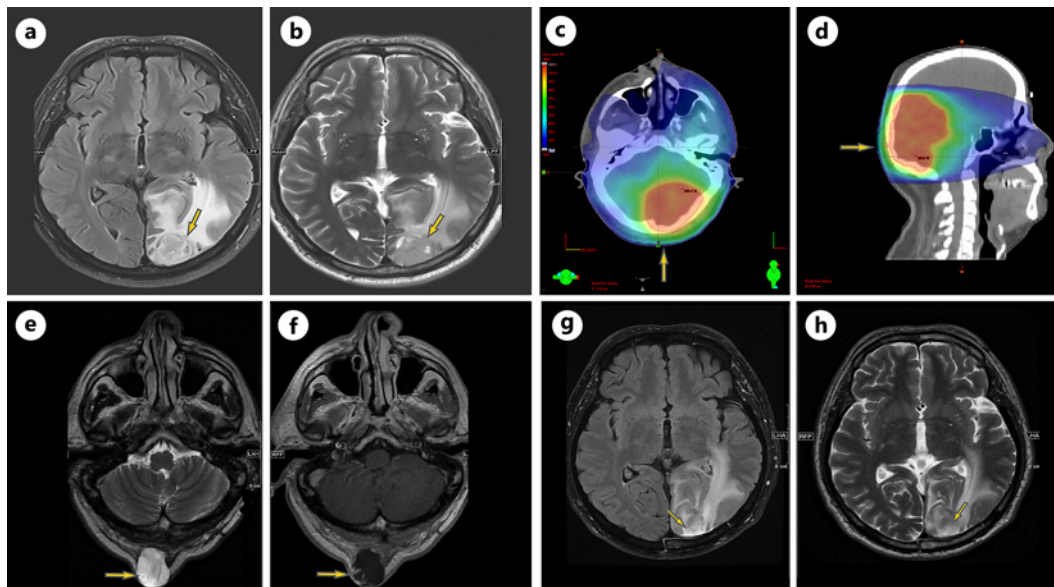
Axial FLAIR (a) and T2WI (b) images show a heterogenous left occipital lobe cortical base intra-axial mass that is predominantly high on T2WI. c, d Radiotherapy plan for high-grade glioma, showing the dose to the what later became an STS. e, f Interval development of extracranial suboccipital mass demonstrates heterogeneous high-signal intensity on T2 and peripheral enhancement and nodularity on post-contrast T1WI. g, h Interval progression of the recurrent high-grade left occipital tumor on FLAIR and T2WI.
